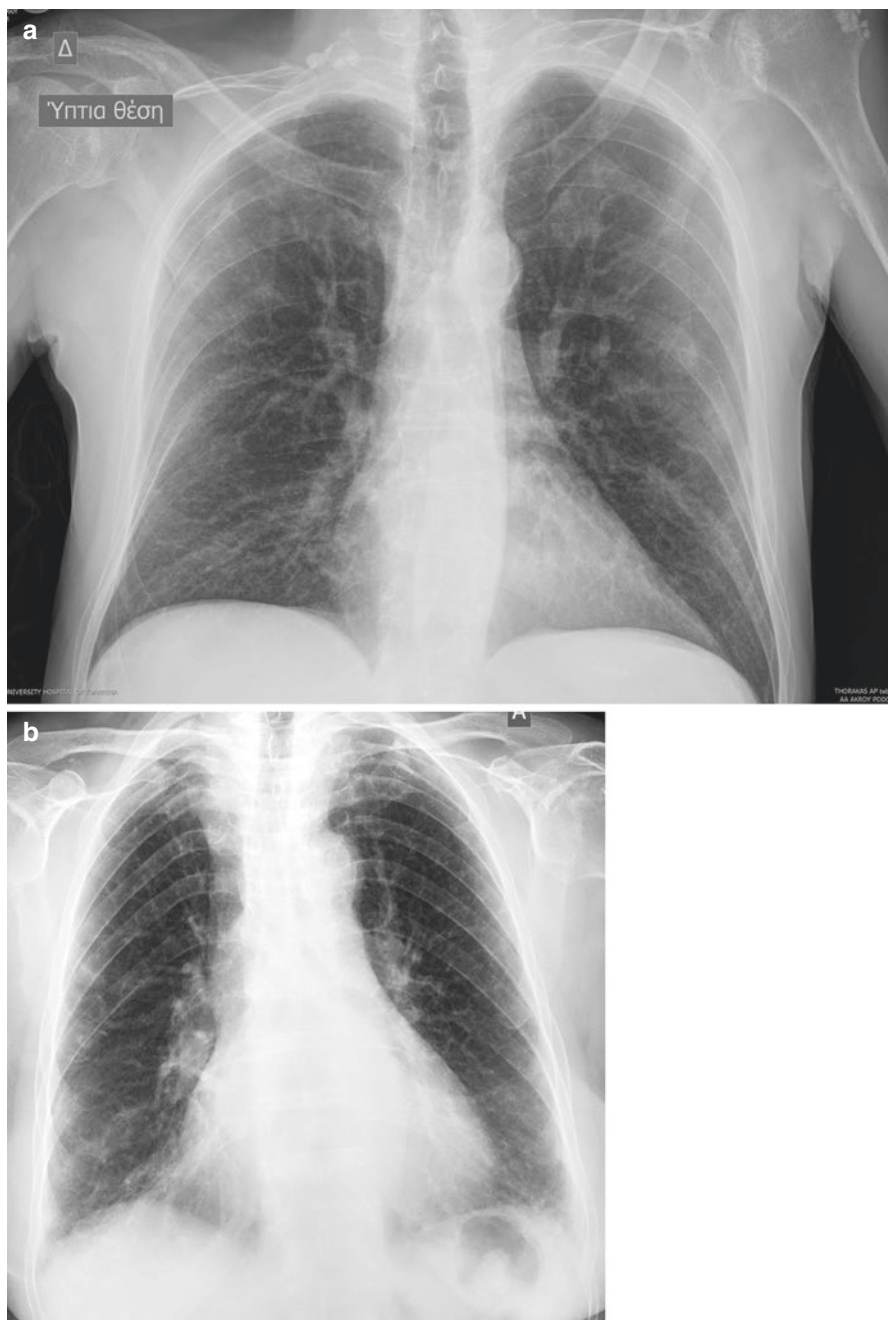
Interstitial lung disease x-ray
